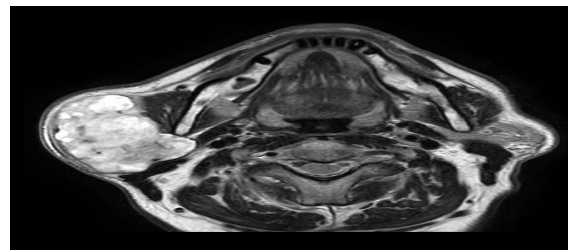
Axial T2-weighted image showing a large tumor extending into the retromandibular space in the right parotid gland.
